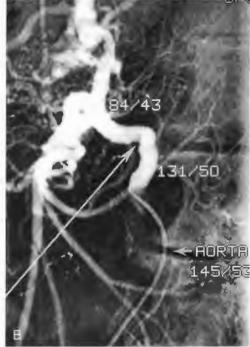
A*, Duplex ultrasound surveillance examination of an SMA bypass graft revealing an elevated PSV of 300 cm/sec. *B*, The angiogram below the duplex demonstrates a kink in the graft (*arrow*) with a corresponding pressure gradient of 47 mm Hg at the region that was insonated. The patient subsequently underwent prophylactic graft revision.
